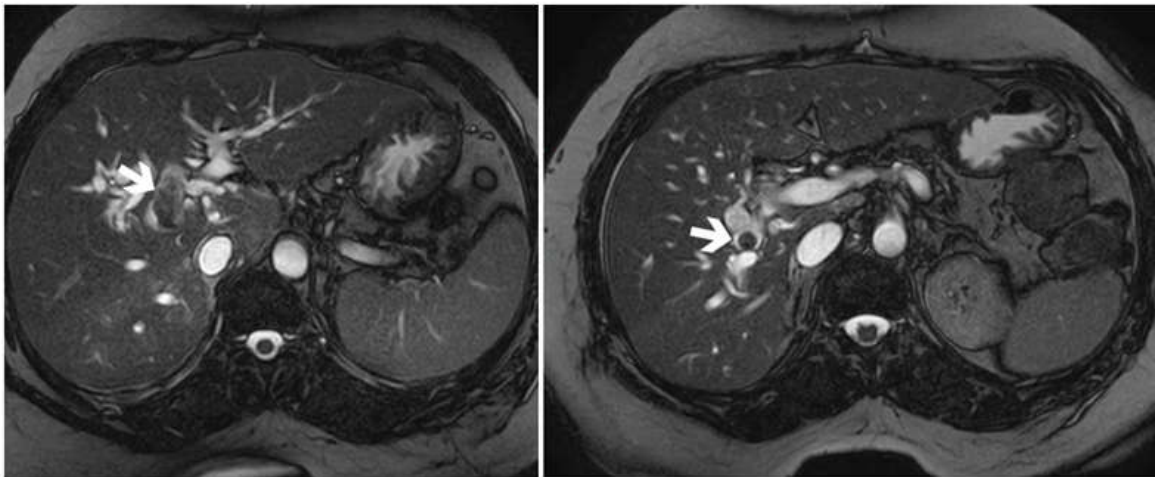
Axial BTFE MR images show a large calculus at biliary confluence (A) with dilated bilobar intrahepatic biliary radicals with smaller calculus in right posterior hepatic duct (B)
